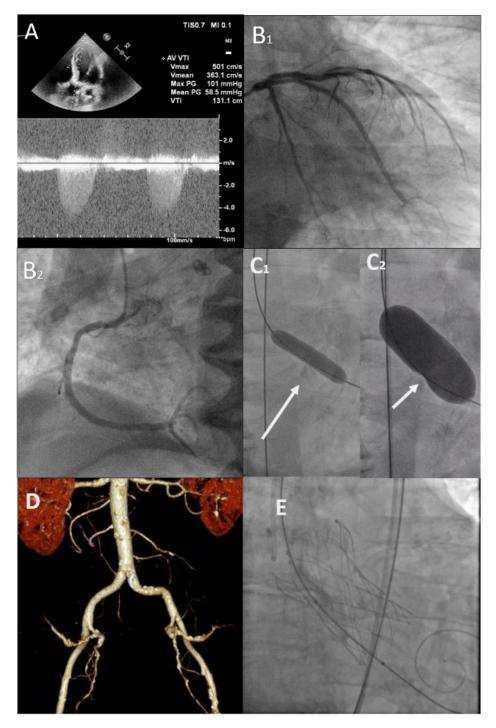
A. Baseline transthoracic echocardiography showing severe aortic valve stenosis. B1. Coronary angiography of the left coronary system with no significant lesions. B2. Coronary angiography of the right coronary artery with moderate lesion in its proximal segment. C1. 9.0×50 mm peripheral angioplasty balloon that passed across stenosed valve. C2. Final 22×50 mm valvuloplasty balloon (white arrows — calcifications). D. Computed tomography angiography assessment showing optimal femoral access. E. Self-expanding aortic valve implantation
